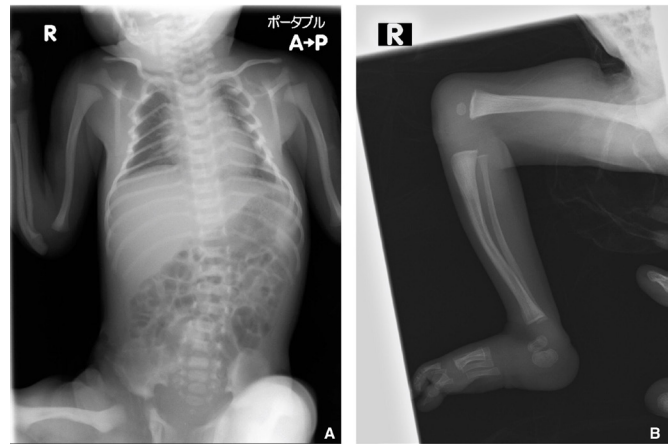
The X-ray of the baby on day 4. (A) The baby has scoliosis and her humerus is bowed. (B) The tibia is bowed which resembles the one shown in fetal ultrasound.
